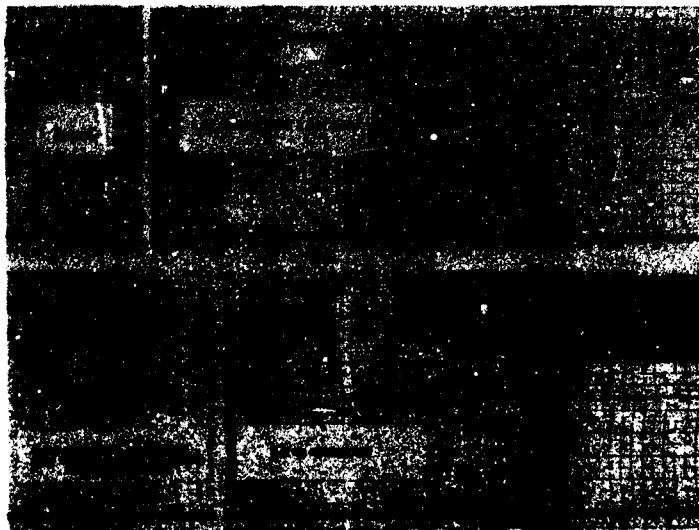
NEGATIVE INOTROPIC EFFECT (UPPER TRACINGS) AND POSITIVE INOTROPIC EFFECT (LOWER TRACINGS) OF ACETYLCHOLINE AND EPINEPHRINE, RESPECTIVELY, ON THE ISOLATED HEART PREPARATIONS.
